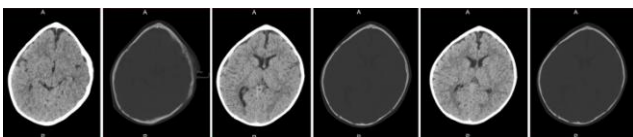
Axial cross section head CT scan: note the triangular forehead, prominent midline sagittal ridge and shortening of the anterior cranial fossa, with compensatory bulging of the parieto-occipital region and temporal narrowing
